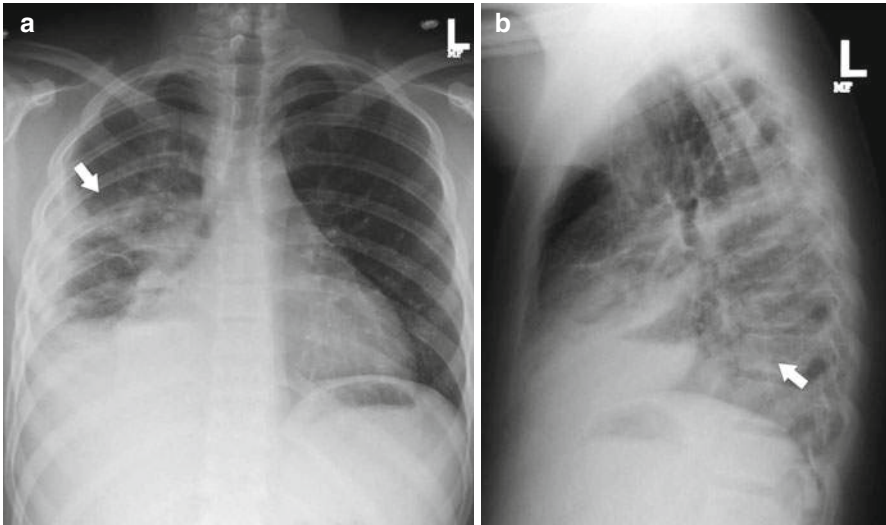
Pneumonia. Chest X-ray posteroanterior (a) and lateral (b) chest views show pneumonia (arrows) in the right lower lobe
